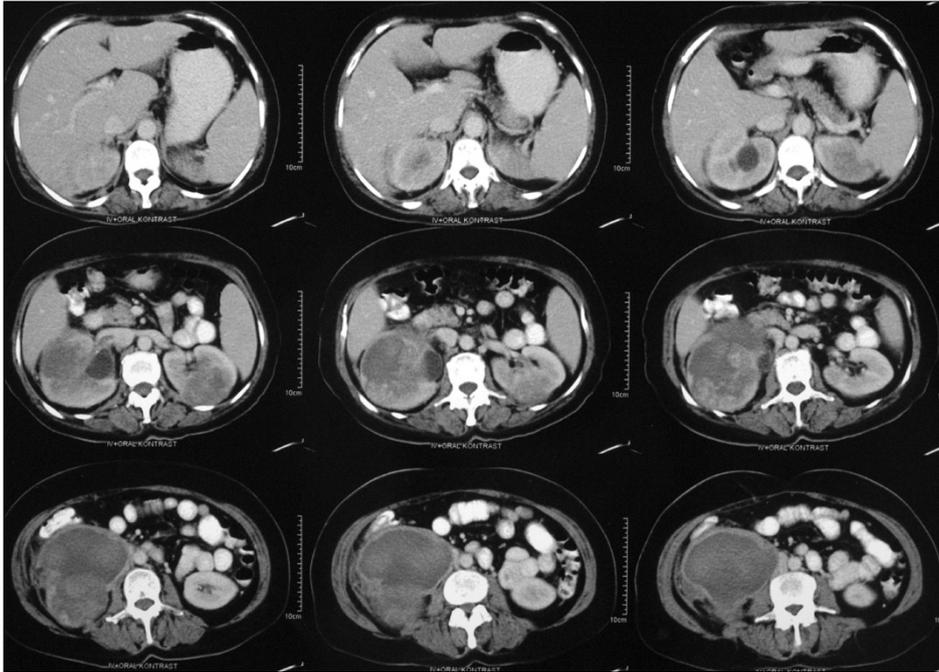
Abdominal CT scan showing bilateral renal masses.
